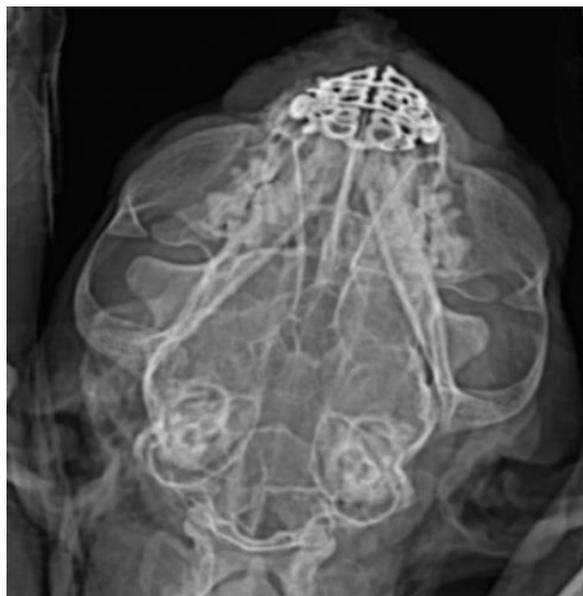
Postoperative 4<sup>th</sup> month Skull Radiography V/D
